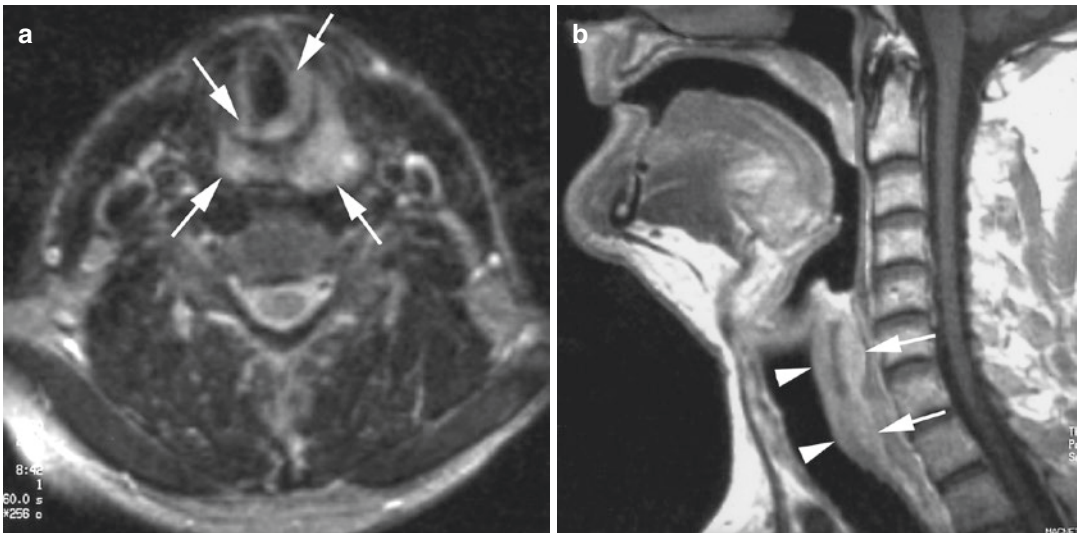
Patient presenting with hoarseness; endoscopically, a submucosal mass lesion is suspected. The axial T2-weighted MR image (a) shows a hyperintense mass lesion (arrows) in the subglottis and distal hypopharynx. On
